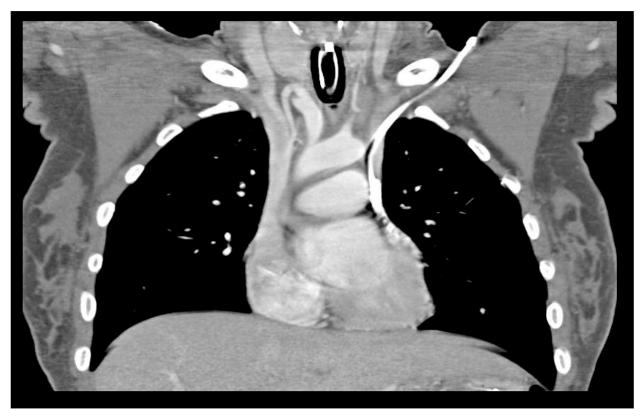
CT coronal view, Central Line in the Left SVC
